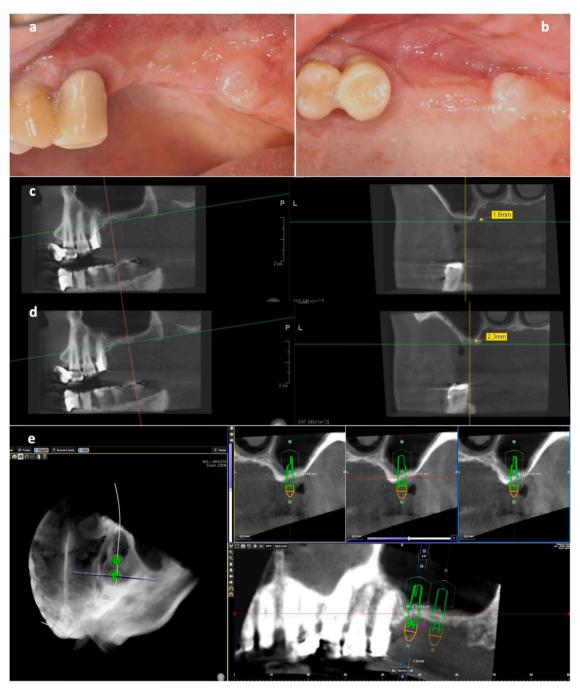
preoperative clinical images (a, b) and CBCT analysis at the implant sites (c, d).
